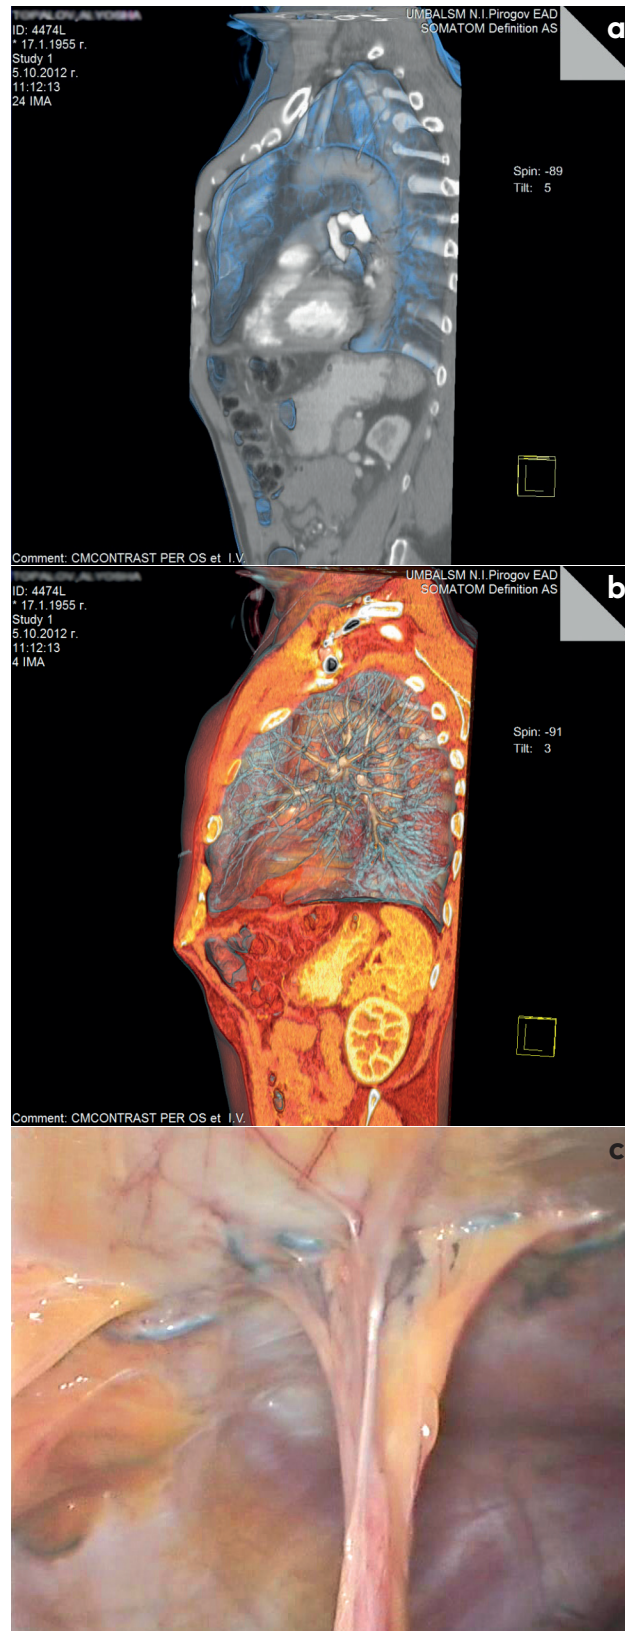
(a, b) Three-dimensional computed tomography performed 25 months after the operation demonstrating an intact hernioplasty. (c) Laparoscopic view 25 months after the operation demonstrating intact hernioplasty and a few peritoneal adhesions.
